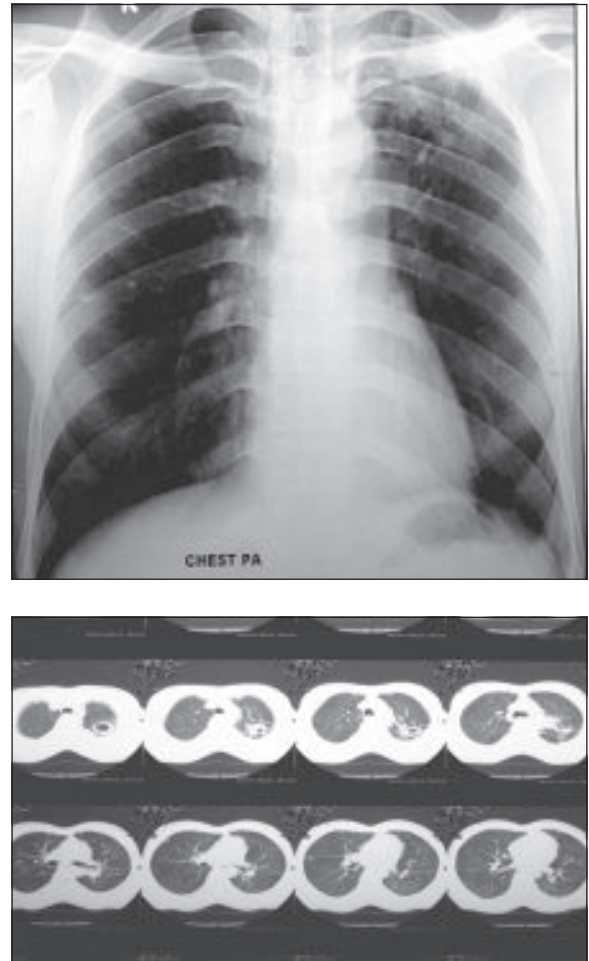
Chest x-ray and CT scan of Aspergilloma of Left Upper Lobe.
